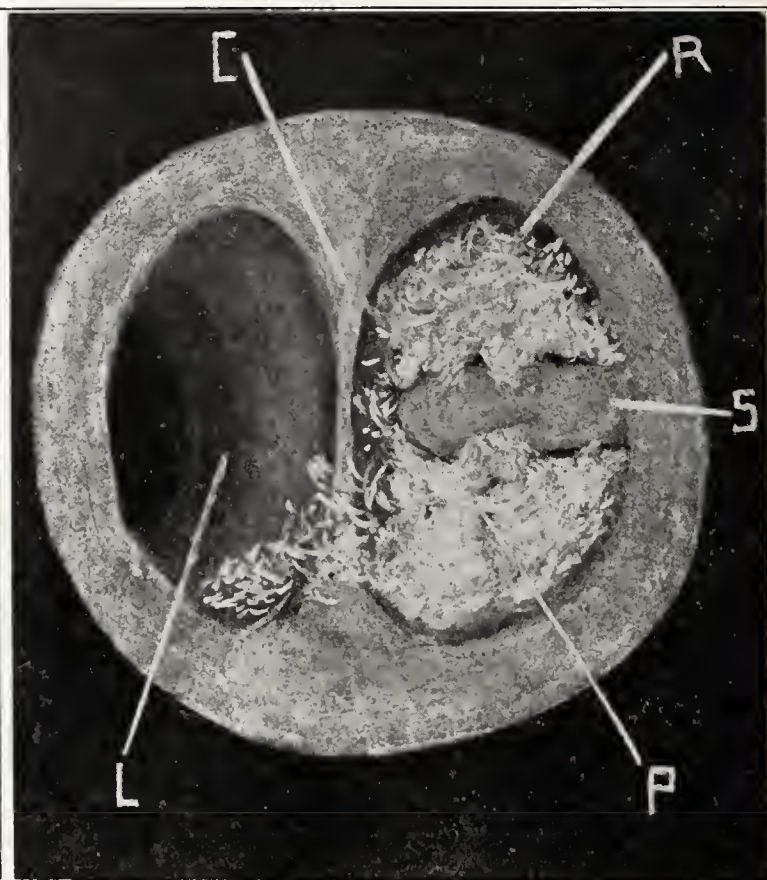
Sketch of bronchoscopic view of watermelon seed in right main bronchus. Extensive secondary changes have not occurred. S—Watermelon seed. R—Right main bronchus. P—Foamy secretion accumulated above and below the seed and spilling over across the carina (C) into the left main bronchus (L). This "internal drainage" of secretion into the left bronchus accounts for the abnormal physical findings on the left side. The pus was removed by bronchoscopic suction and the foreign body was then withdrawn. Patient made a complete recovery, and the x-ray picture returned to normal.
